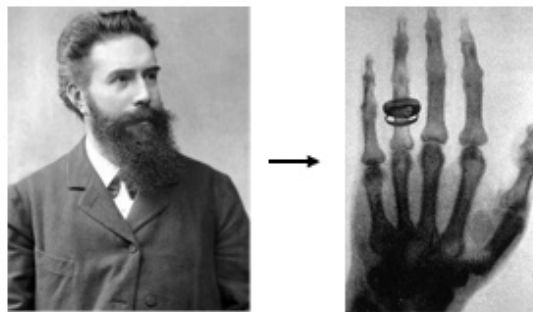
First medical image taken from X-rays.
